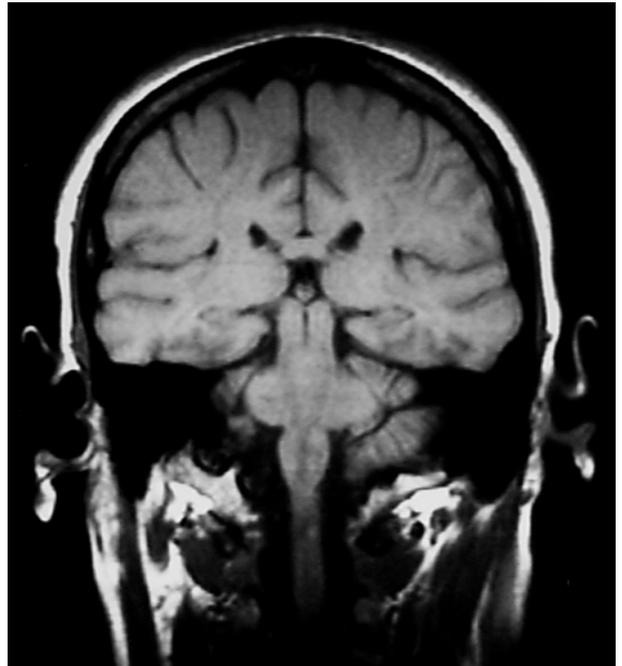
An inverted MRI scan showing the epithalamus with its main components the pineal gland and habenula. Observe their relationship to the third ventricle
